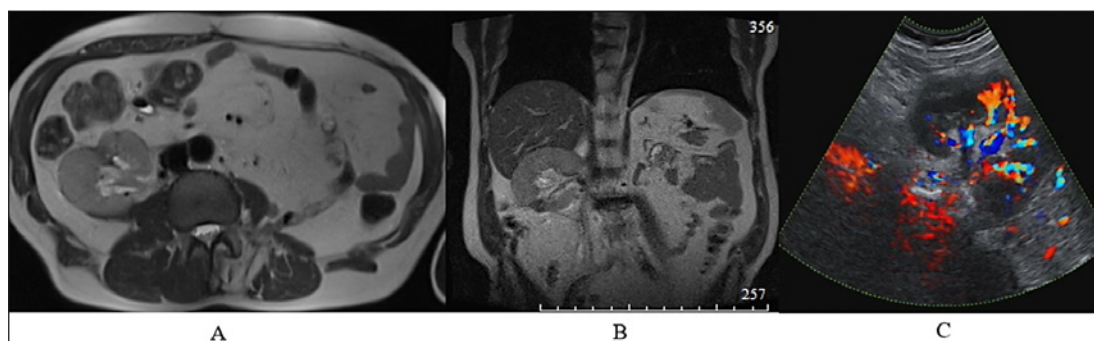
Sixteen months after the operation: magnetic resonance imaging of the kidney (A axial plane; B coronal plane) demonstrates the post-surgical defect of the kidney, but no recurrent tumour. C Ultrasound image of the kidney proves adequate blood flow.
